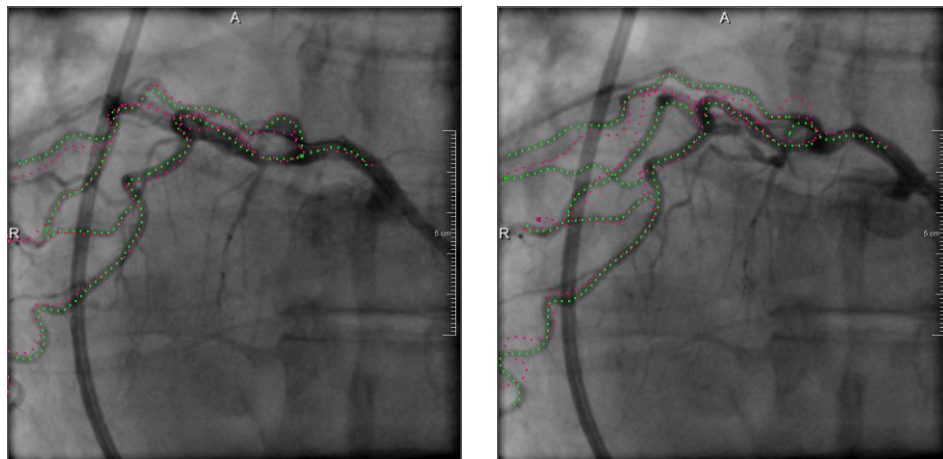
Best (left) and worst (right) alignments according to the ranking established for time-sequences 1, 2 and 3.1. The images are X-ray frames with manual annotated centerline in green and the closest projected centreline in pink.
